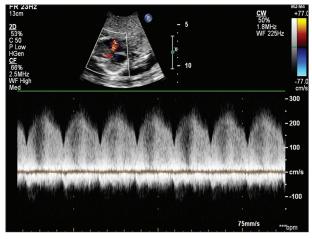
Continuous wave Doppler across the PV demonstrating systolic and diastolic PR
